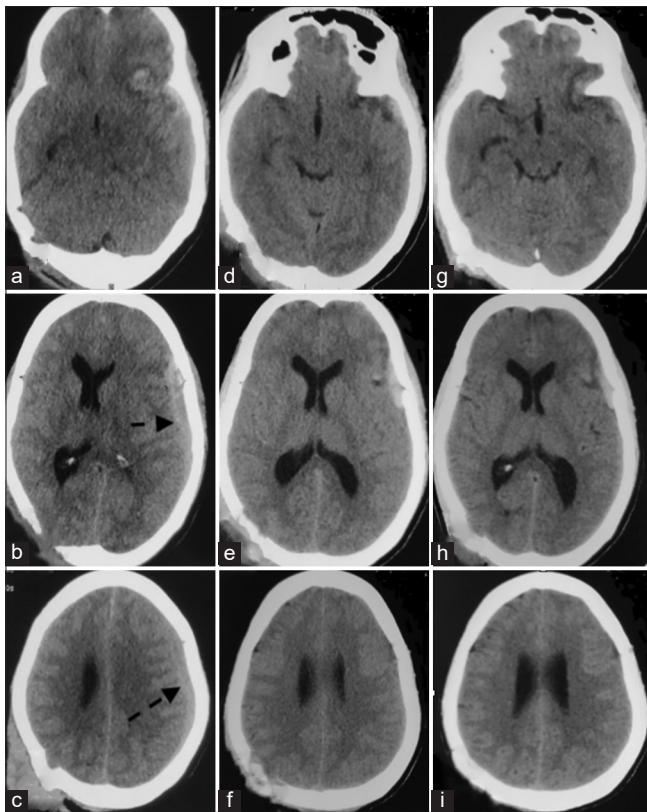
(6 h after trauma) (a) Basal axial image showing obliterated basal cistern with left basifrontal contusion. (b and c) (6 h after trauma)-9.6 mm mixed density SDH in left fronto-temporo-parietal region (marked with broken arrow) with midline shift of 6 mm (d-f) (13 h after trauma)-computed tomography scan showing complete resolution of mixed density part of clot with small residual hyperdense part of clot with open basal cistern and no midline shift. (g-i) (day 5 after trauma) Computed tomography scan showing resolving left basifrontal contusion and residual left frontal SDH
